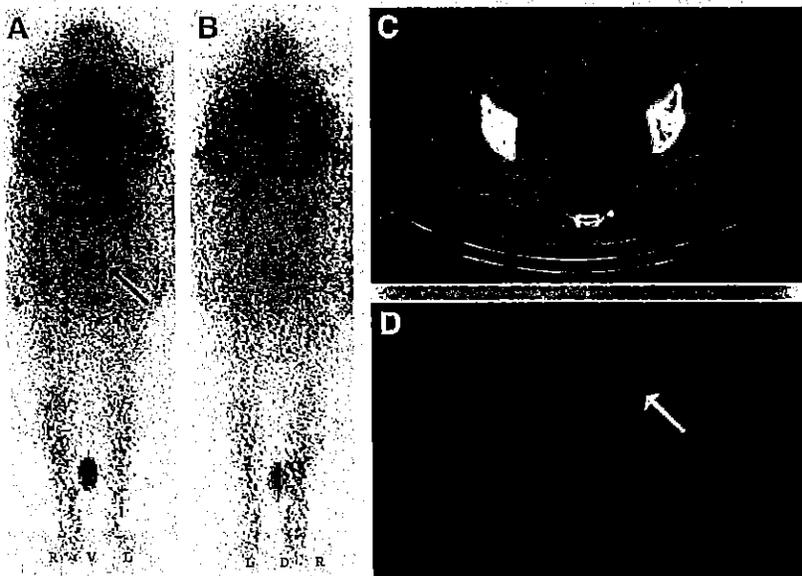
Exact delineation of focal pelvic ^{131}I uptake in patient with differentiated thyroid cancer. (A and B) Planar ^{131}I scintigrams (anterior view [A] and posterior view [B]) showing focal tracer uptake in left pelvic region (arrow). Lesion cannot be definitely assigned as benign or solitary bone metastasis. (C and D) Corresponding CT section (C) and fused SPECT/CT image (D) demonstrating non-specific tracer uptake in diverticulum of colon (arrow).
